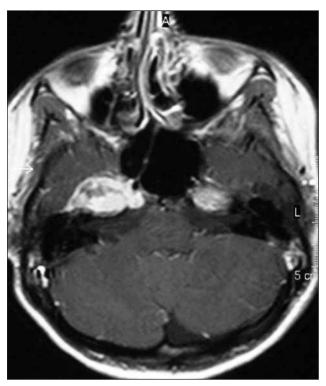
T1W MRI of the right greater superficial petrosal nerve cellular schwannoma compressing the right abducens nerve at Dorello's canal (case 7).
